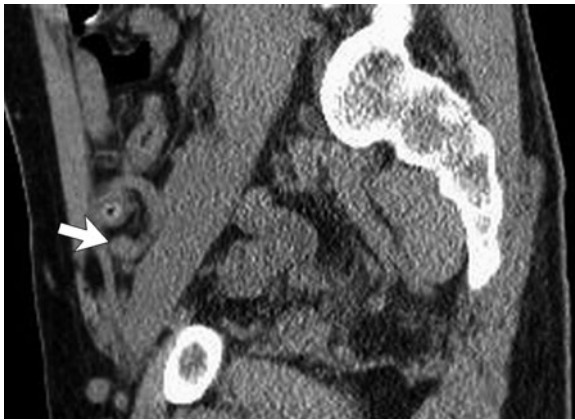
Incidental sub-cm carcinoid tumor at the appendiceal tip. Sagittal CT image shows bulbous enlargement at the tip of the appendix (*arrow*), which was asymptomatic and proved to be a small carcinoid tumor at surgical resection
